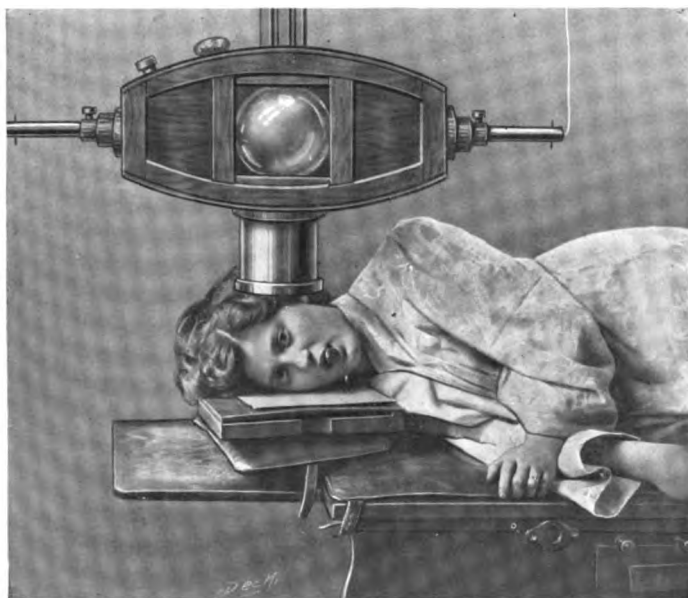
Radiography of the frontal sinus, from the side.
